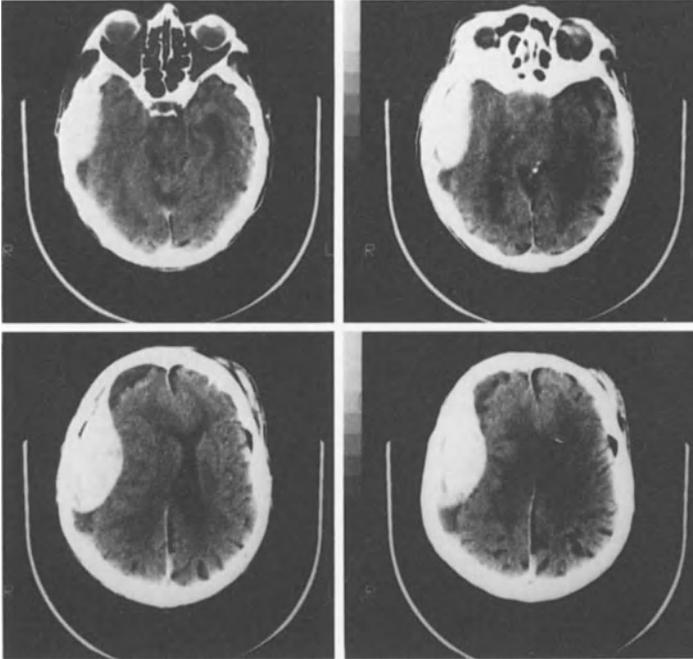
K.M., 91 years old, preoperative CT: Subdural hematoma with occluded perimesencephalic cisterns and midline shift more than 4 mm
